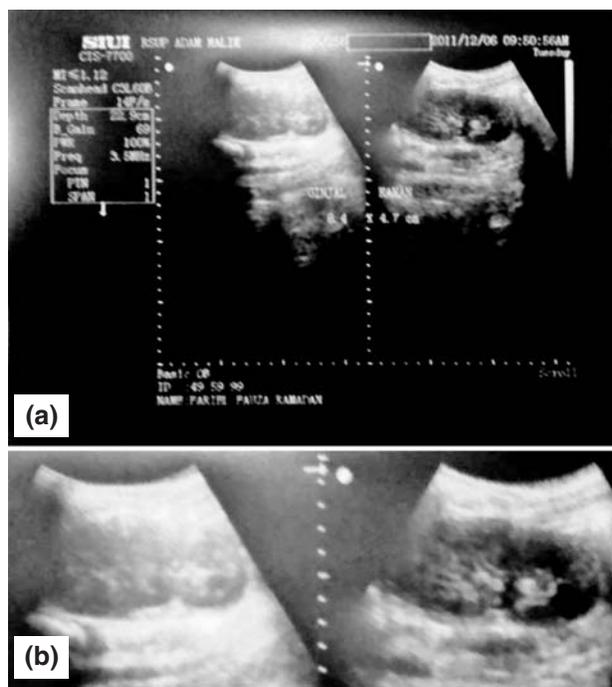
Renal ultrasound in Case 2. (a) Parenchyma was normal. Echo structure of cortex and medulla did not differentiated well. Left and right kidney sizes were 7.5 x 5.2 cm and 8.4 x 4.7 cm, respectively. (b) Magnified renal ultrasound
